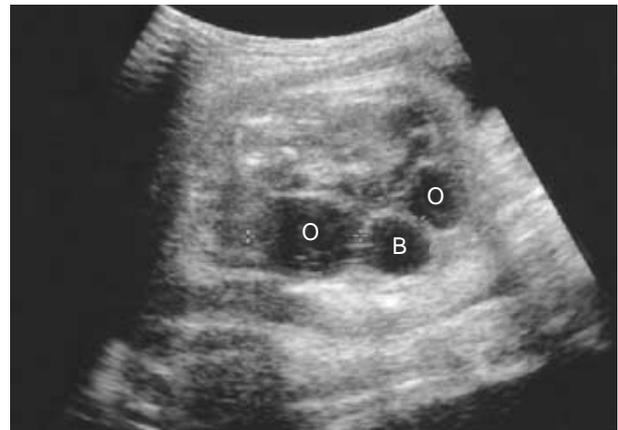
Bilateral ovarian cyst: prenatal sonography at 33 weeks of case 14 which are spontaneously regression at 4 month after birth. B, bladder; O, ovary.
